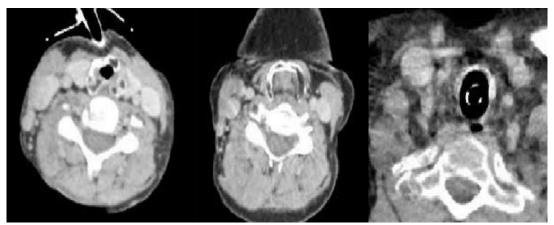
Cervical CT scan in axial sections showing dystrophic calcifications of the cricoid and thyroid cartilages and tracheal rings.
